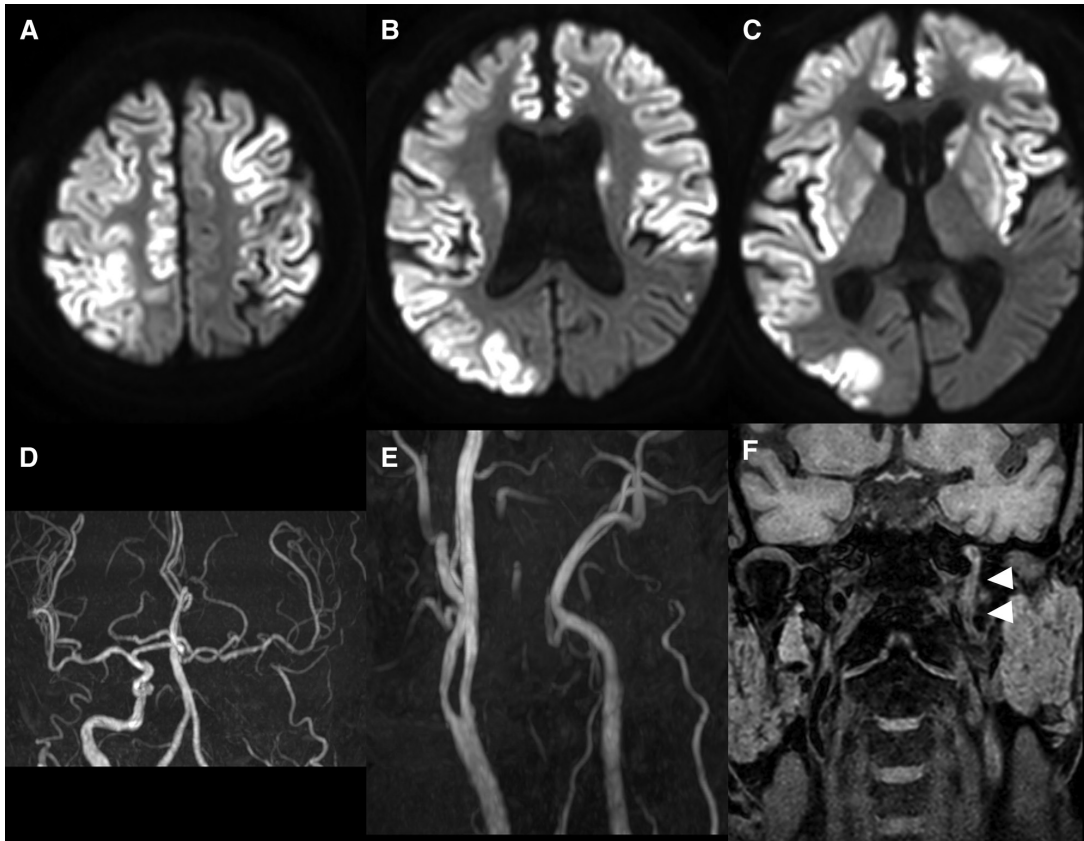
Brain MRI and MRA the day after mechanical thrombectomy. (A–C) Diffusion-weighted images showing extensive infarction in the bilateral cerebral hemispheres. (D) Brain MRA showing that all intracranial large vessels were patent except for the left ICA. (E) Cervical MRA showing that the left ICA remained occluded. (F) MR black-blood image (coronal view) showing hyperintense signals in the left cervical ICA (arrowheads), probably indicating chronic occlusion. ICA: internal carotid artery
